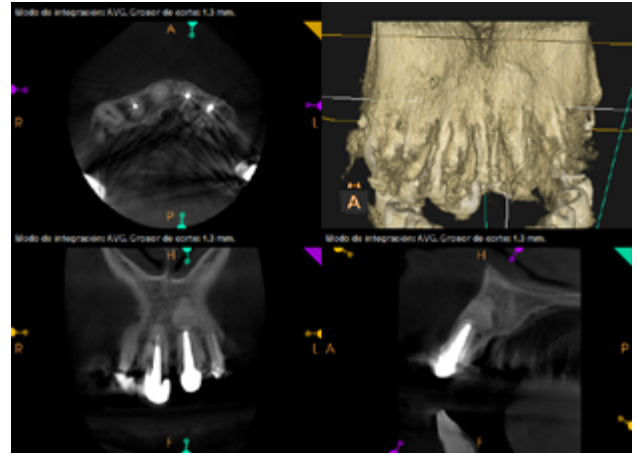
Control tomographic image at the level of 21, 18 months after periapical microsurgery with guided bone regeneration; healing of the pre-existing periapical radiolucent lesion can be seen.
